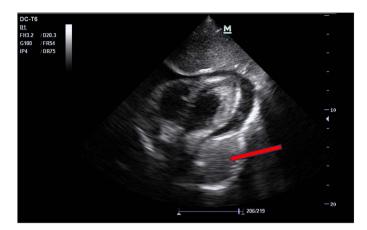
Echocardiography; subcostal showing intrapericardial mass with pericardial effusion (red arrow).
